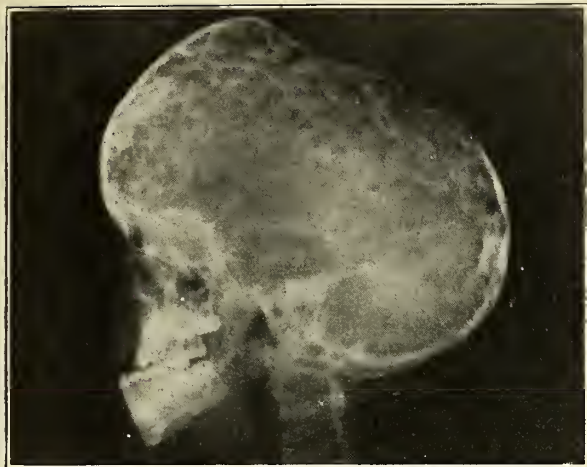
(Case A380861). Lateral roentgenogram of an oxycephalic head.
